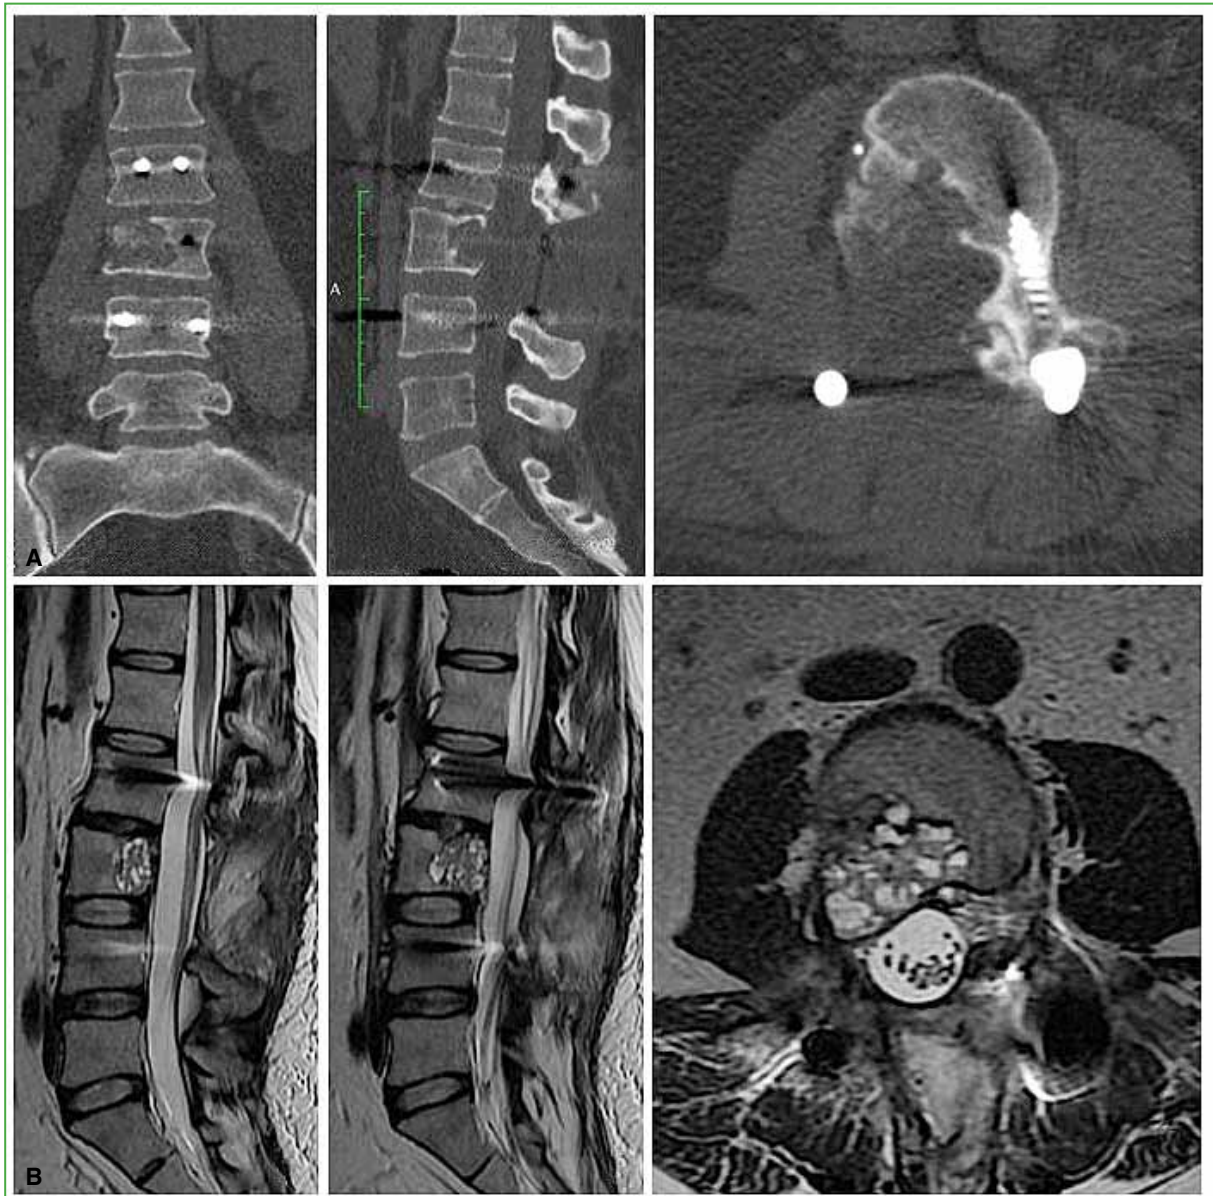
Computed tomography (A) and magnetic resonance imaging (B) six months after surgery. The recurrence of the tumor is observed.
